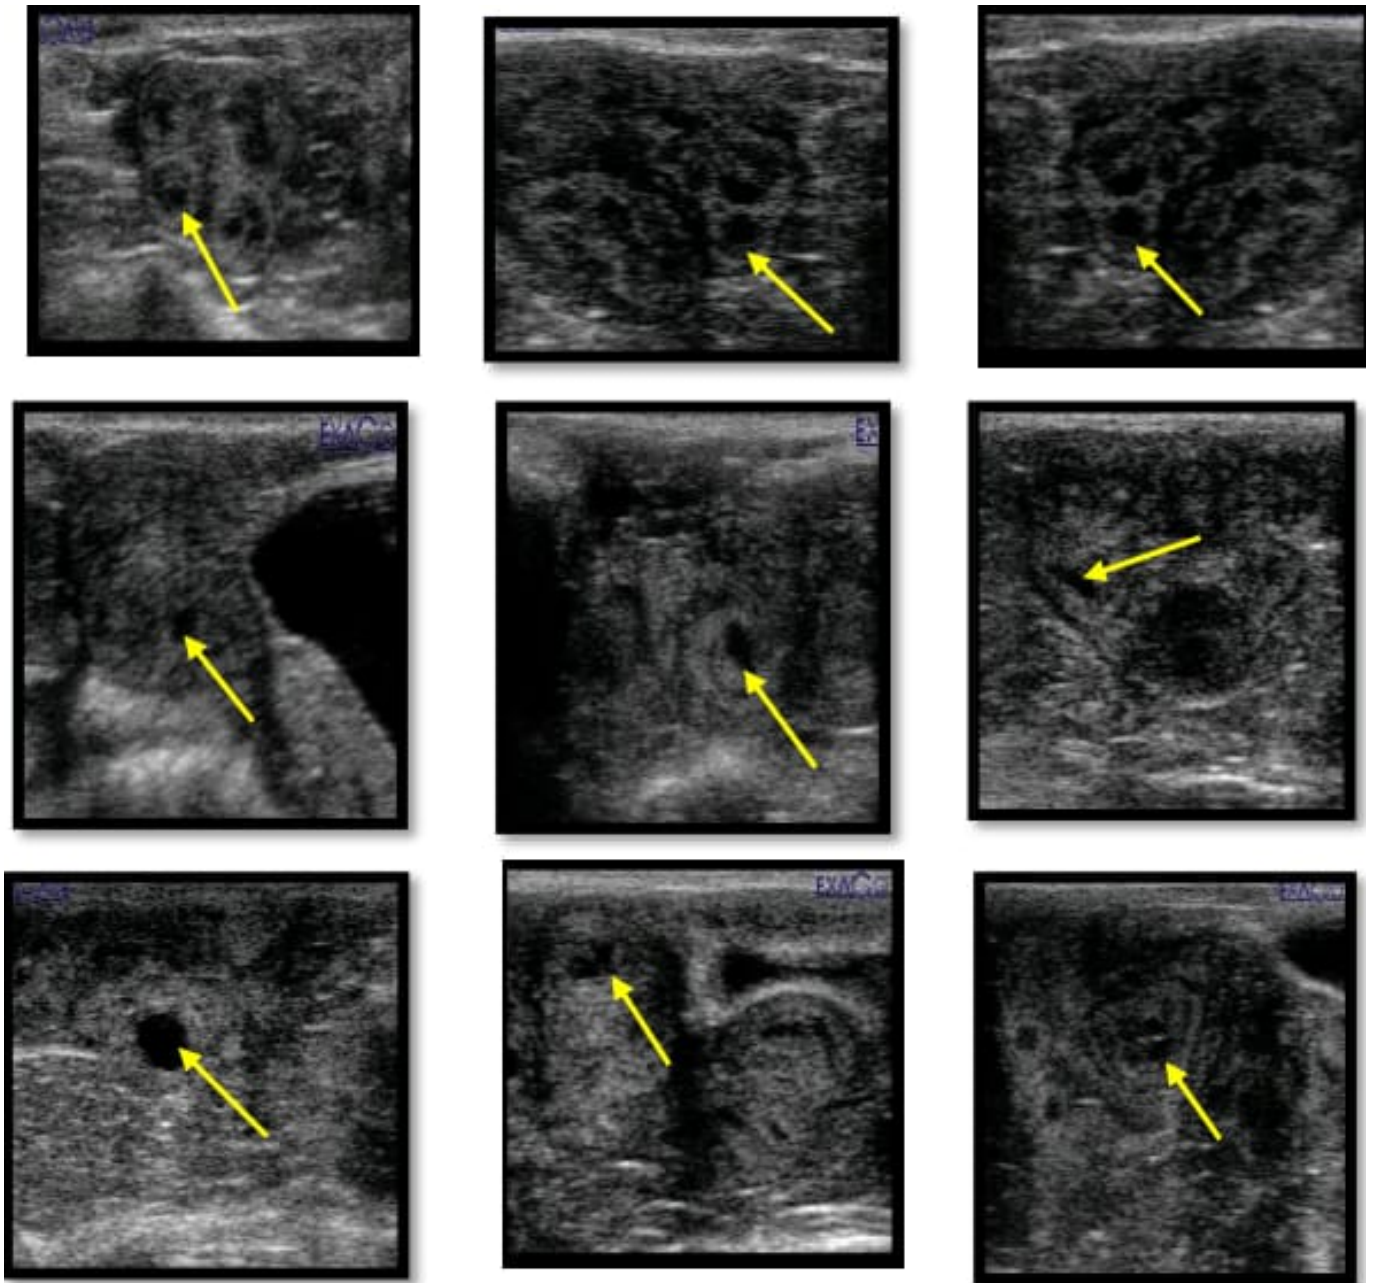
Ultrasound findings of uterus During early luteinization in nonpregnant ewes, of letrozole treated ewes showed fluid accumulation (yellow arrows) on uterine lumen
